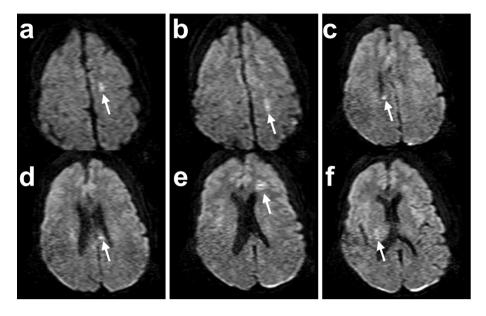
Antemortem magnetic resonance images of the victim scanned 2 weeks after his injury. Axial diffusion-weighted images (b: 1000 s/mm^2) are shown. High-intensity lesions, whose distribution is consistent with typical traumatic axonal injury, are apparent in the left parasagittal white matter (a, b), left and right corpus callosum (c, d), deep white matter around the anterior horn of the left lateral ventricle (e), and the right posterior internal capsule (f).
